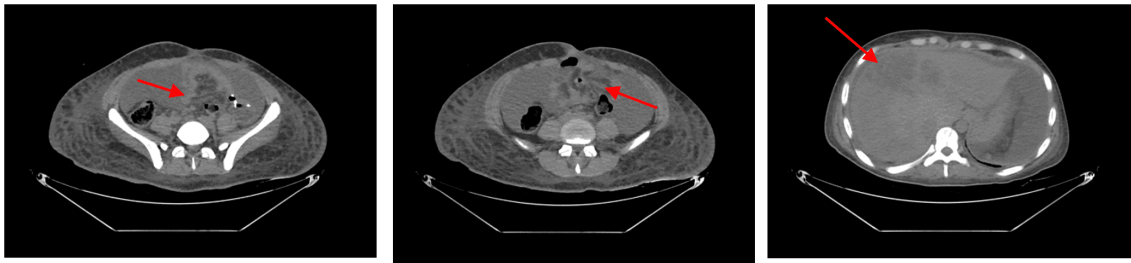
Abdominal non-contrast CT showing mass and hepatic nodule suggesting metastasis
